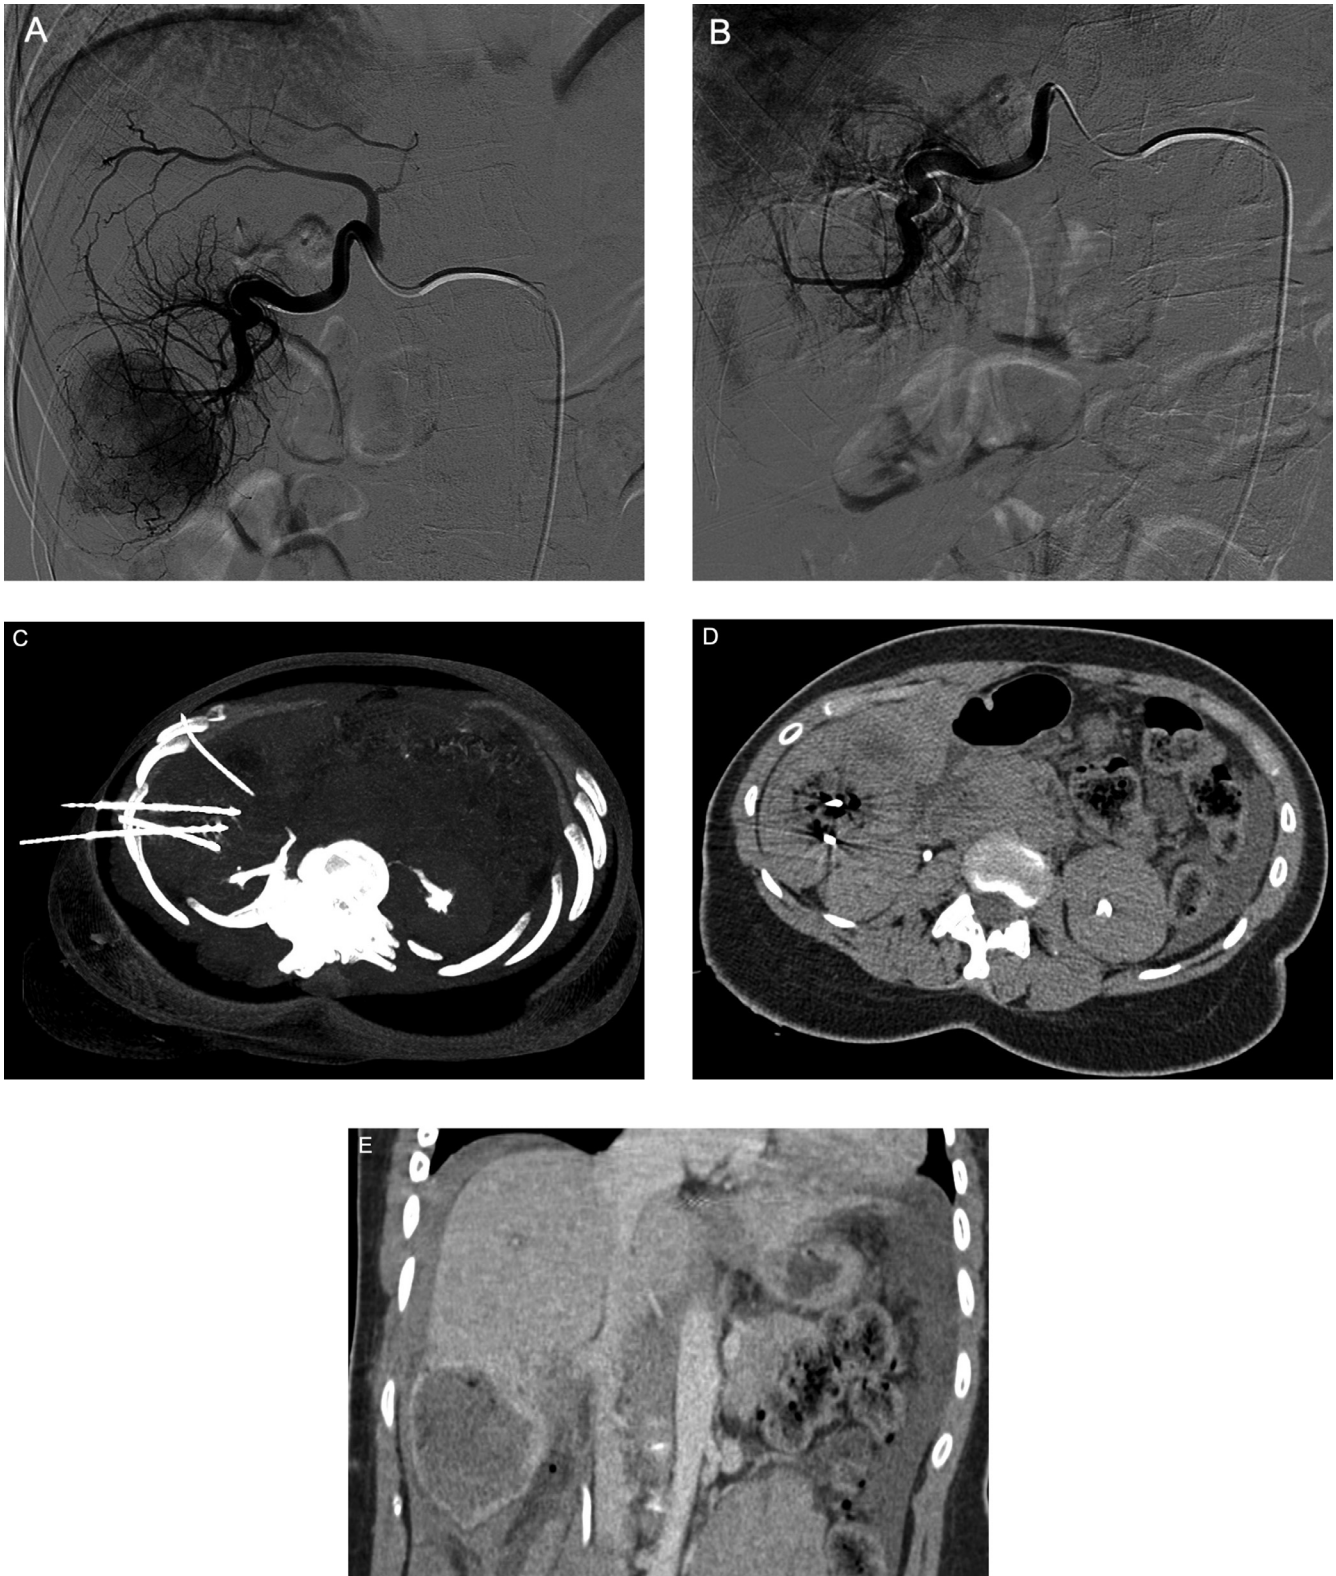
(A) Hepatic angiogram demonstrating large enhancing lesion in segment 6, supplied by the right hepatic artery. The segment 6 lesion was embolized with 100-300 μ m Embospheres. (B) Postembolization angiogram shows no residual enhancement of the liver mass. Approximately 1-week after embolization the patient underwent CT-guided microwave ablation. (C) Maximum intensity projection of 3 Neuwave PR-15 microwave ablation probes positioned within the segment 6 lesion. The anteriorly-placed catheter was used to administer saline for hydroinfusion. (D) Postablation axial and (E) coronal CT shows complete ablation of the mass with no residual enhancement
